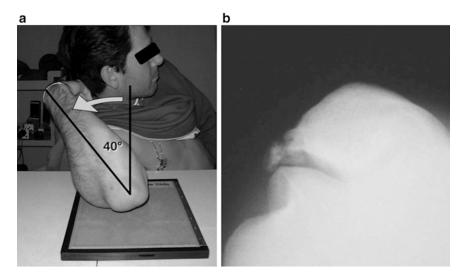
Special radiographs to assess posterior impingement. (a) The Conway X-ray is performed to visualize the posteromedial olecranon and associated osteophytes. An AP X-ray is taken with the elbow in full
